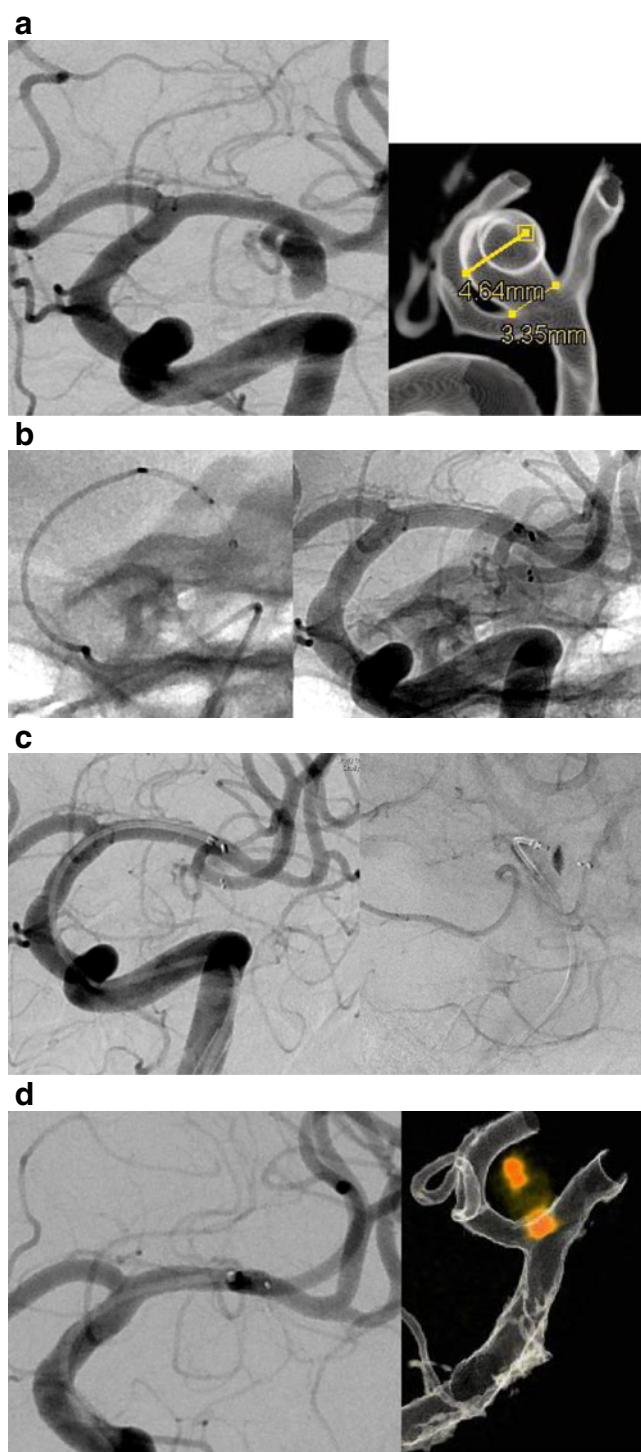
a Arteriogram of the left internal carotid artery p.a. view showing a MCA aneurysm with a diameter of max. 7×4.6 mm. The diameter of the neck was estimated to be 3.4 mm. The 3D reconstruction demonstrates the broad base of the bifurcation aneurysm in relation to the parent vessel. b Arteriogram of the left internal carotid artery (unsubtracted view). The WEB II device is passed through the 0.027 microcatheter. Note that the WEB II device has three markers. c Arteriogram of the left internal carotid artery p.a. and lateral view immediately after deployment showing immediate cessation of flow within the implant. d Arteriogram of the left internal carotid artery p.a. view and 3D reconstruction showing complete occlusion of the aneurysm within 10 min after deployment. Note that d and g are differently angulated to a which is suboptimal as it does not allow a 1:1 comparison pre- and post-emo to detect a possible neck remnant. Therefore, we added 3D reconstructions prior and immediately after treatment. e Post-interventional CT scan demonstrating a regular situation without the typical artifacts seen after conventional coil occlusion. f Post-interventional axial FLAIR, T2, T1, DWI, GRE, and TOF MR scan at 3 T demonstrating no thrombotic complication and only a few artifacts arise from the WEB II device. g Control arteriogram of the left internal carotid artery p.a. view 8 weeks after treatment showing a persisting complete occlusion of the WEB II-treated MCA aneurysm. Note that the angulation is comparable to d. The 3D reconstruction (not shown) revealed no difference to d
